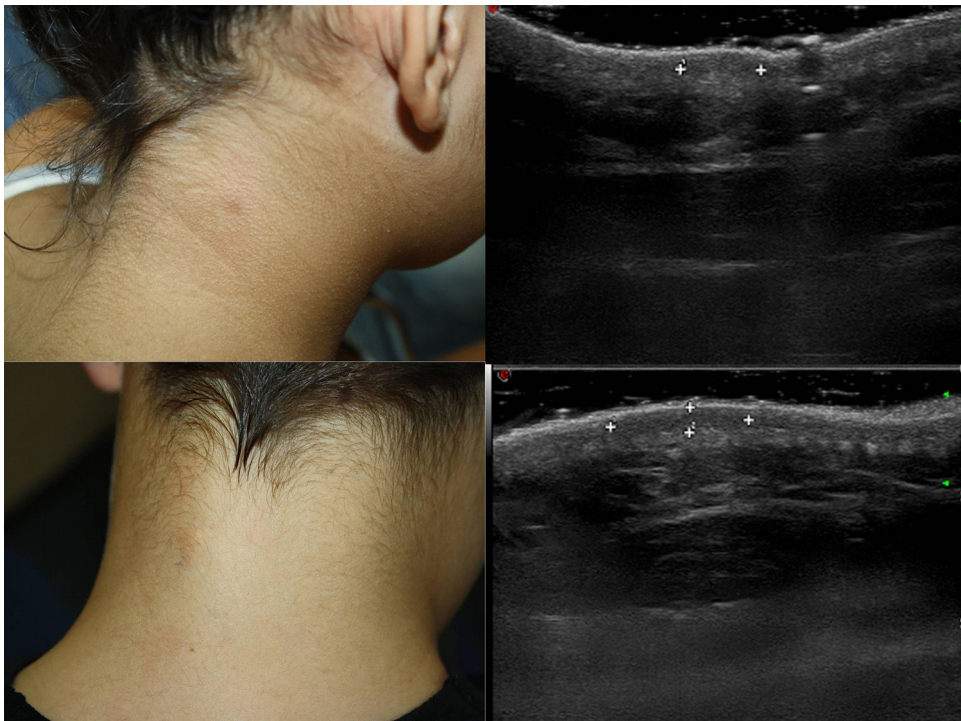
Clinical and ultrasound characteristics.
